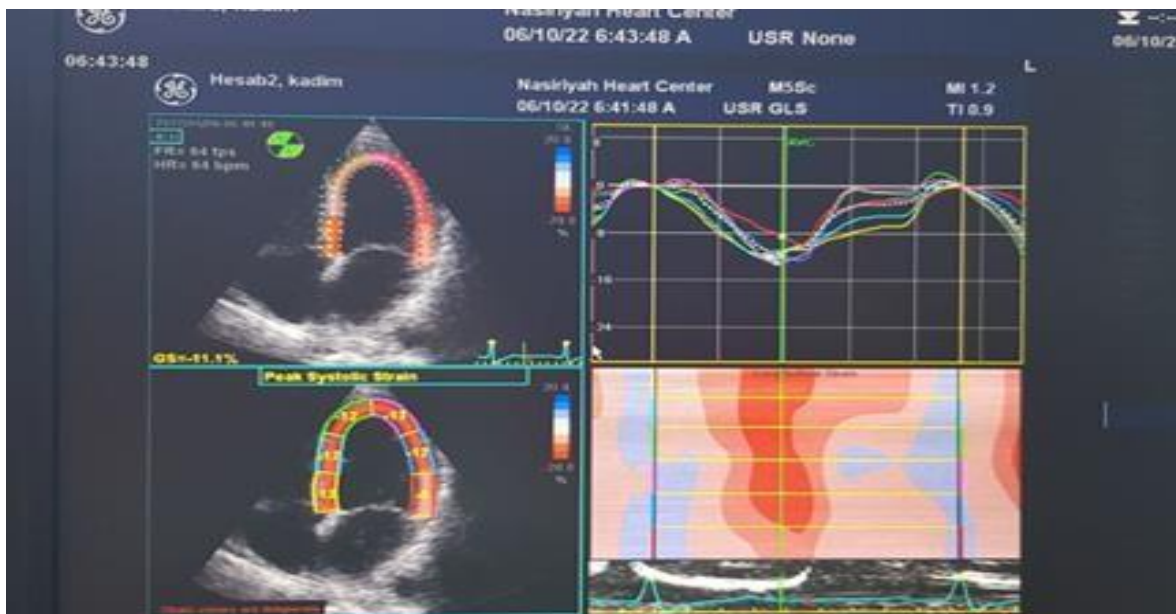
A longitudinal strain by speckle-tracking echocardiography.
